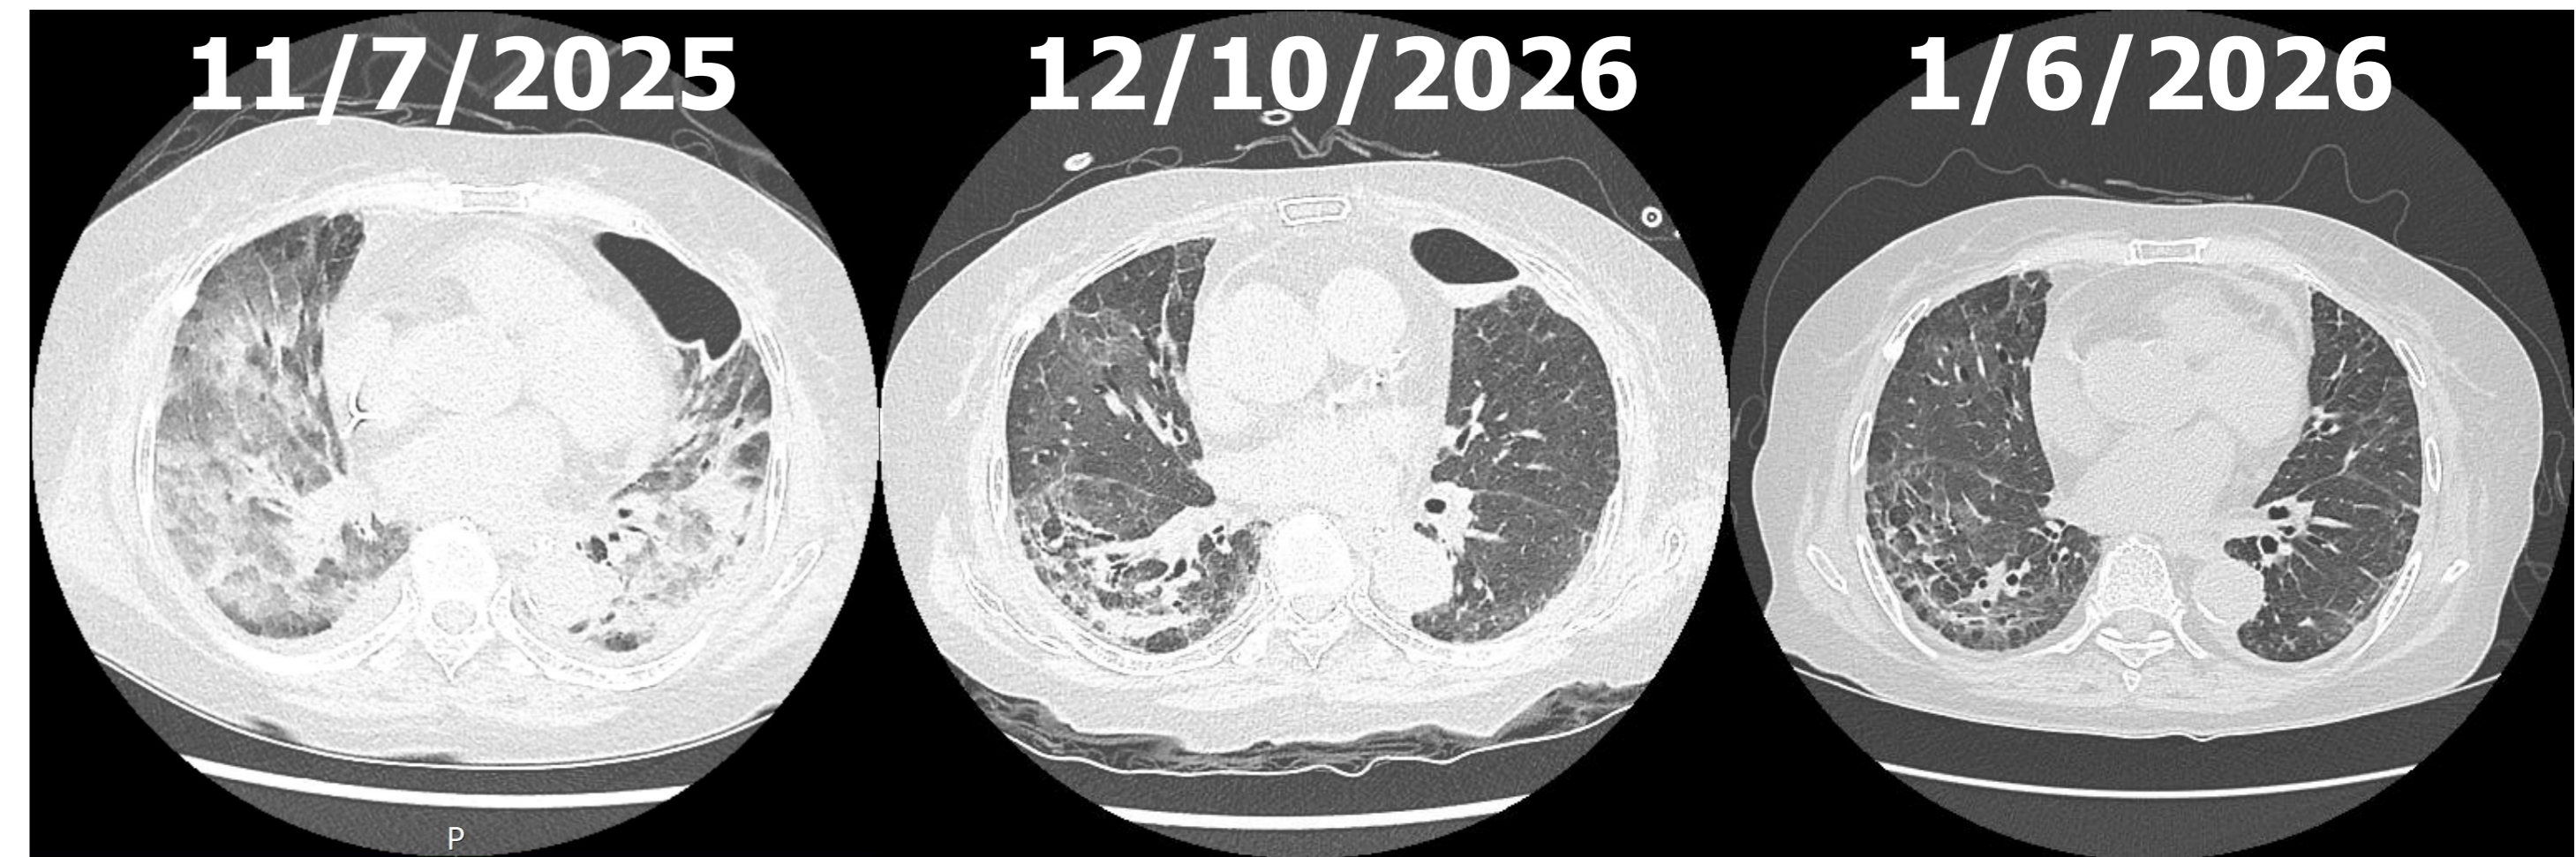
Serial changes in chest computed tomography (CT) scans from admission to recovery
